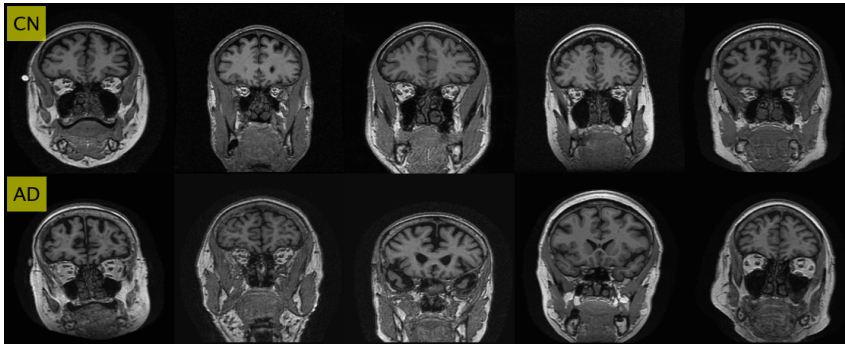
Coronal plane: MRI slice Nr. 77 for CN and AD. Second best selection according to pre-trained CNN features.
